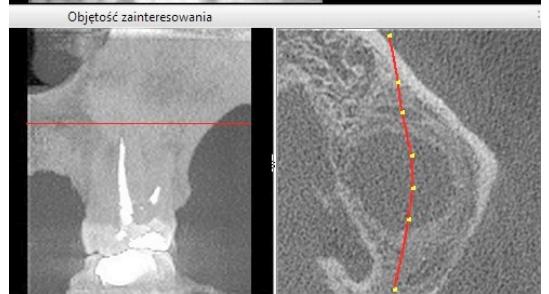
Case 1. CBCT scan showing a large, well demarcated, oval radiolucency surrounding half of the palatal root of tooth 26.
